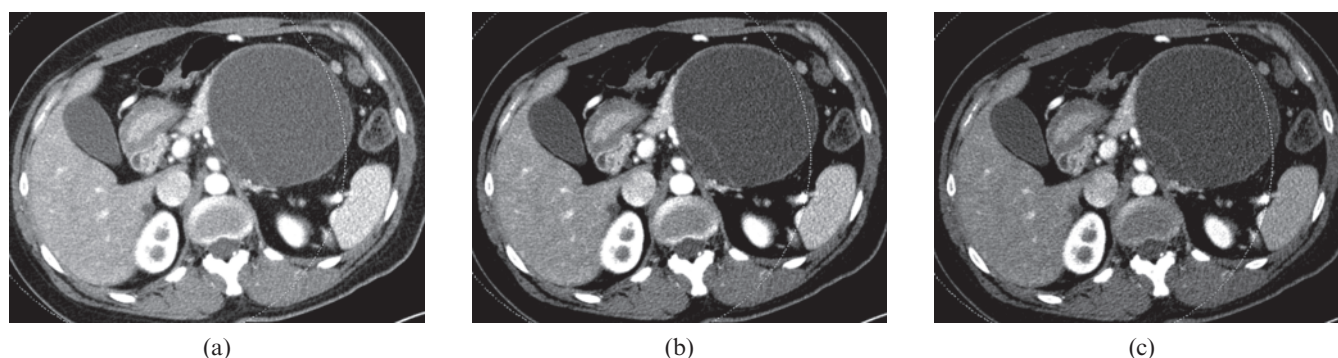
40-year-old female with mucinous cystic adenoma. Dual-energy CT images with a weight factor of (a) 0.3, (b) 0.5, and (c) 0.7, all show a large, cystic mass with the thin wall as well as internal septation in the pancreas tail. The image with a weight factor of 0.3 shows the least noise, although the septation is better visualised as internal septation is on the weight factor 0.7 image. Note that the internal cystic component appears to be coarse on the image with weight factor 0.7. The image with weight factor 0.5 shows relatively higher contrast than the image with weight factor 0.3 and lower noise than the images with weight factor 0.7. Both reviewers selected image (b) as the preferred image.
